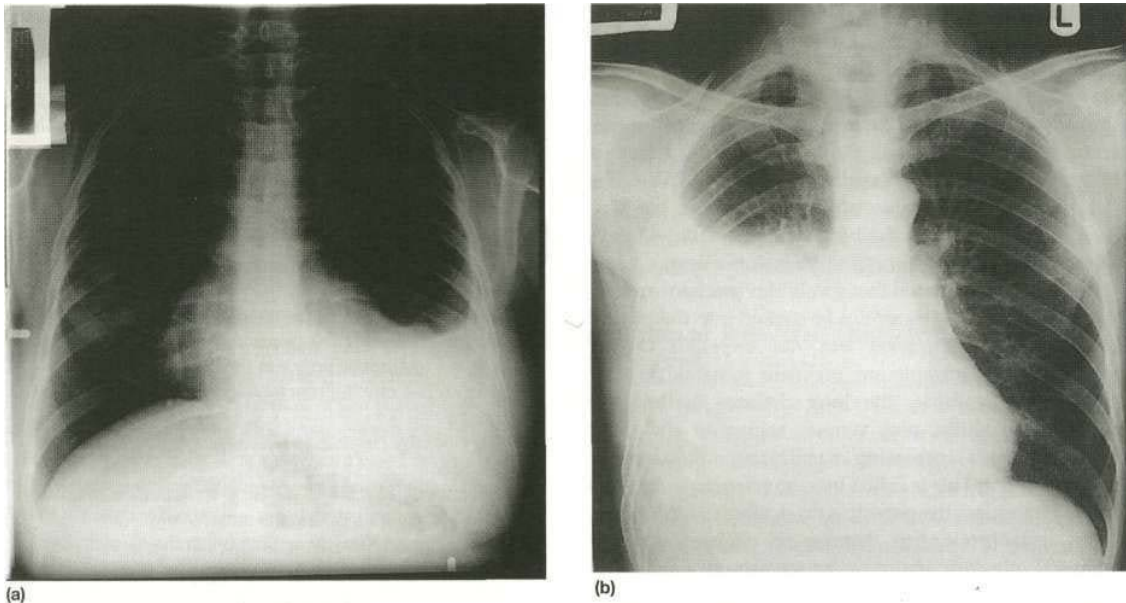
Radiographs showing (a) small and (b) large pleural effusions.
